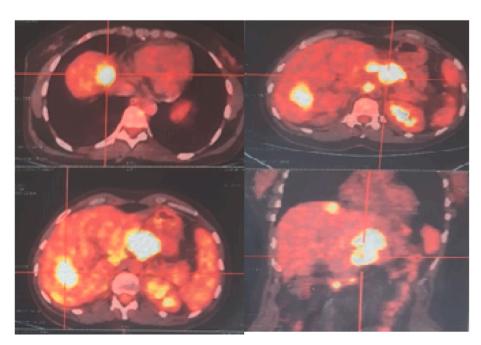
FDG PET showing showed two corporal pancreatic lesions intensely avid for FDG with multiple hepatic secondary lesion.
